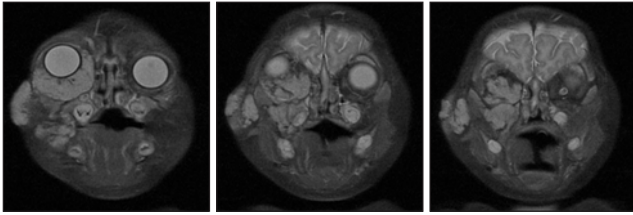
Coronal T2-weighted FSE craniofacial-orbital MRI images, before treatment.
